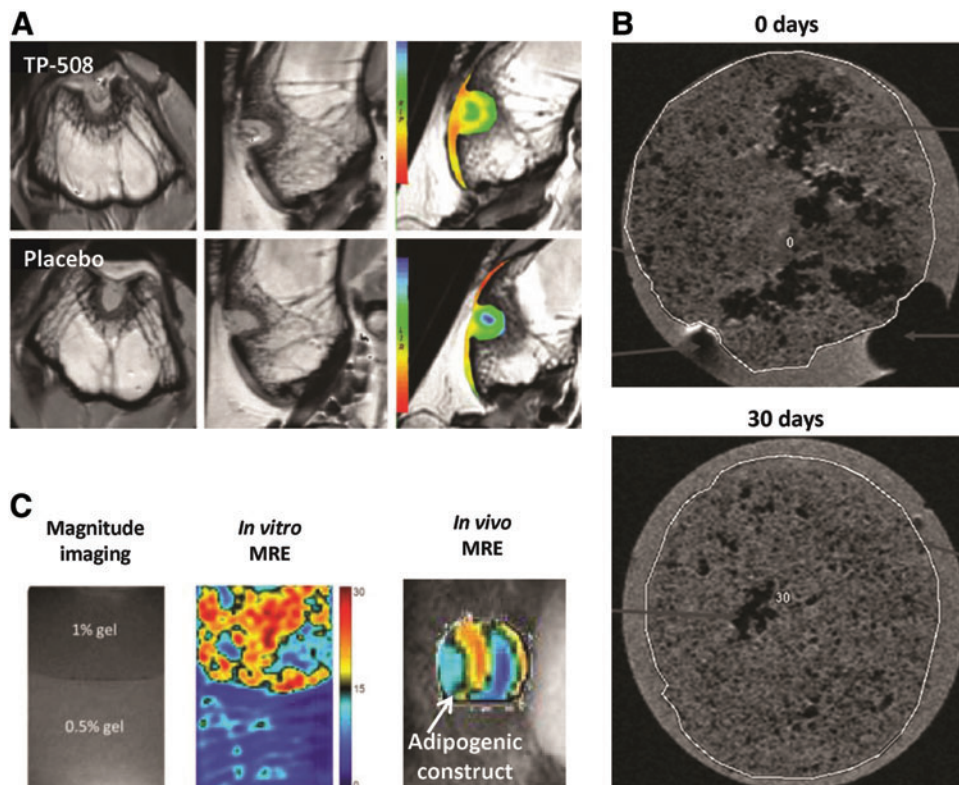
MR imaging to evaluate tissue-engineered scaffolds and wound healing. (A) Cartilage-sensitive MR imaging to evaluate healing within a bone defect model following delivery of thrombin peptide (TP)-508 within PLGA microspheres. Reprinted with permission from Kim *et al.*⁴⁴ (B) MR imaging of SPIO-labeled chondrocytes seeded in polyvinylidene difluoride hydrogels at 0 and 30 days. Reprinted with permission from Ramaswamy *et al.*⁴⁶ (C) Nondestructive monitoring of mesenchymal stem cells-based tissue-engineered constructs using high-resolution magnetic resonance elastography (MRE). Reprinted with permission from Othman *et al.*⁵⁵ Color images available online at www.liebertpub.com/teb
